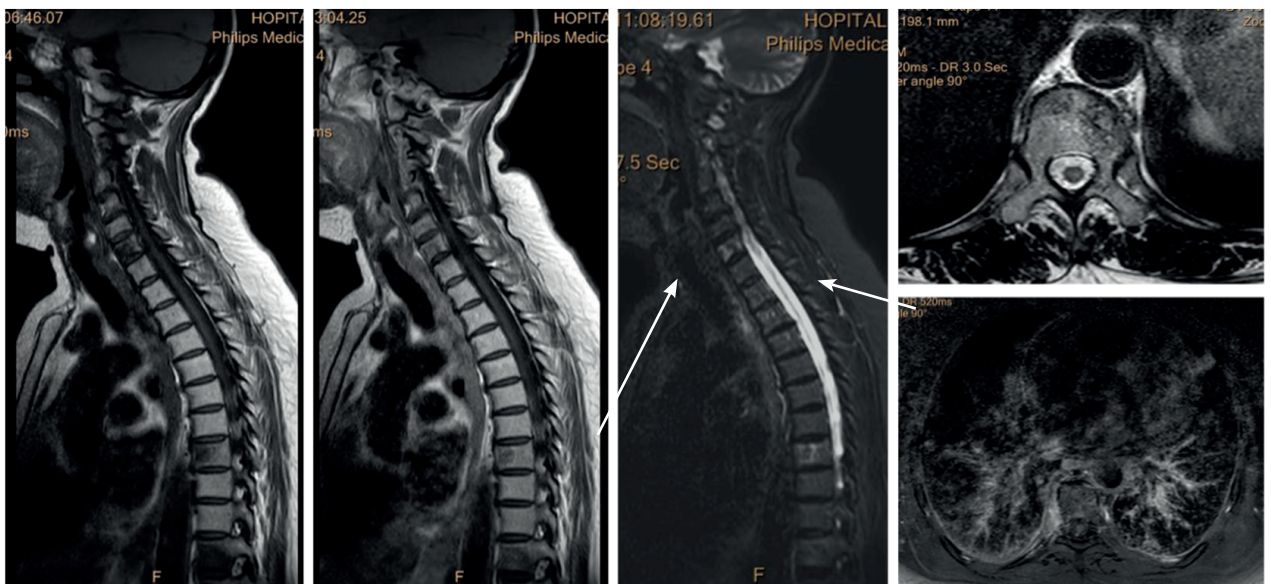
MRI sequences: T1, STIR, T1 after gadolinium injection: multiple infiltrative bone lesions hypointense on T1, hypointense on STIR surrounded by an hyperintense border. These lesions are mildly enhanced after gadolinium injection
